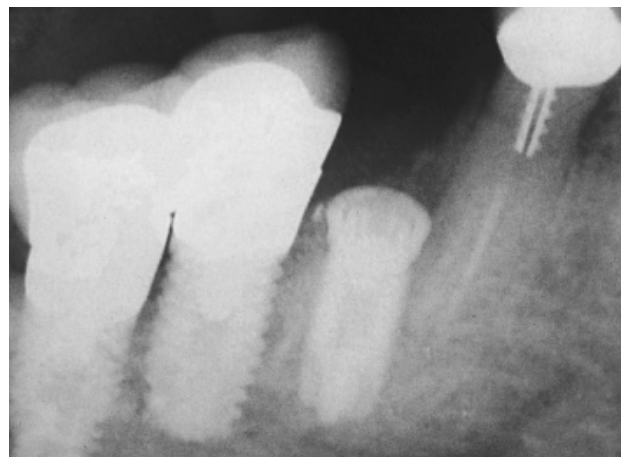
A radiograph taken two weeks postoperatively revealed a radiolucent lesion around the mandibular right first premolar (arrow).
